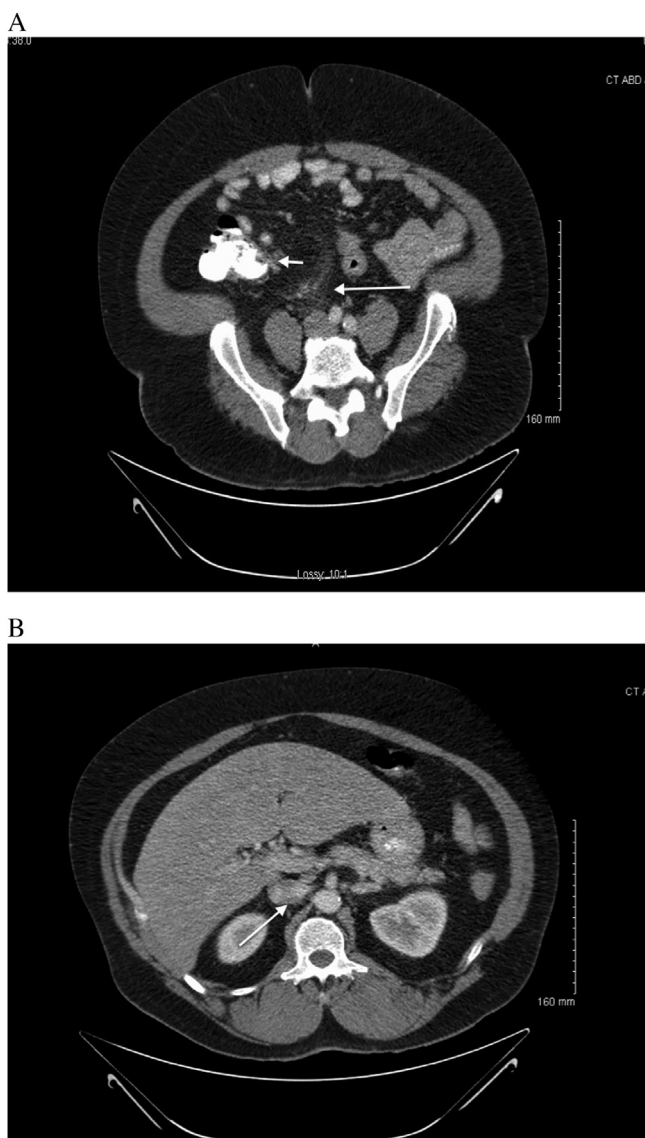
(A) CT abdomen and pelvis with oral and intravenous contrast. Abnormal fat stranding of the mesentery (long arrow) and thickening of the terminal ileum (short arrow). (B) Suspected thrombus at the confluence of the superior mesenteric and portal veins (arrow).
